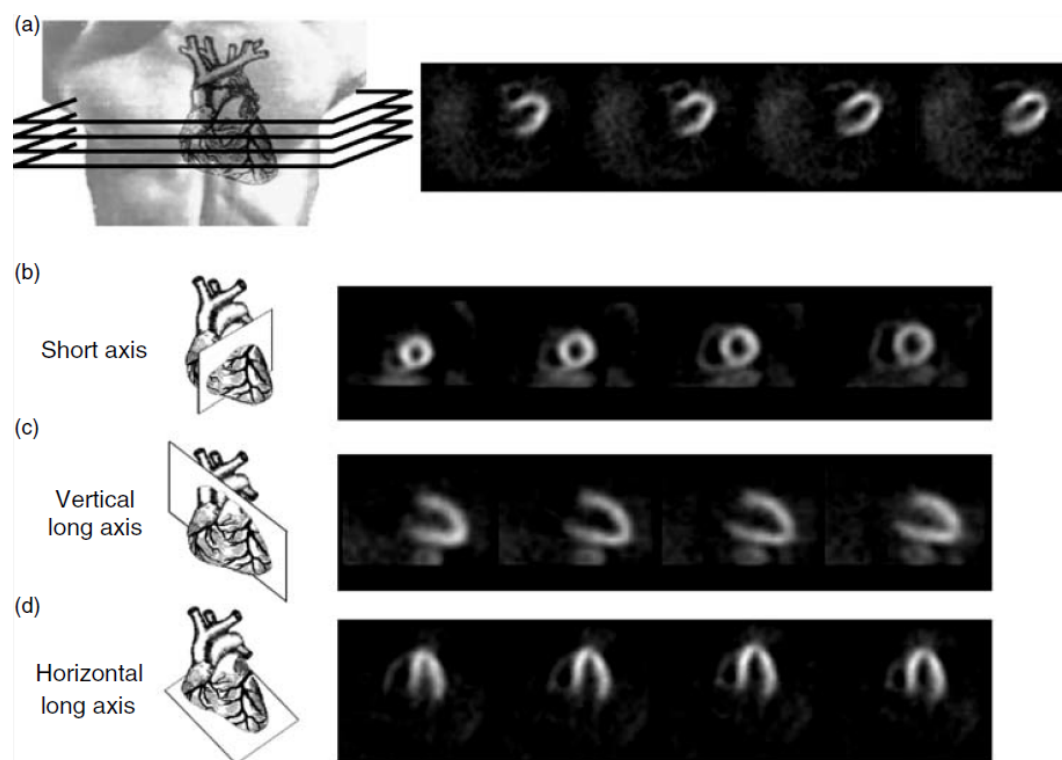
Standard heart orientation for the display of cardiac SPECT studies: SA, HLA and VLA⁵.
